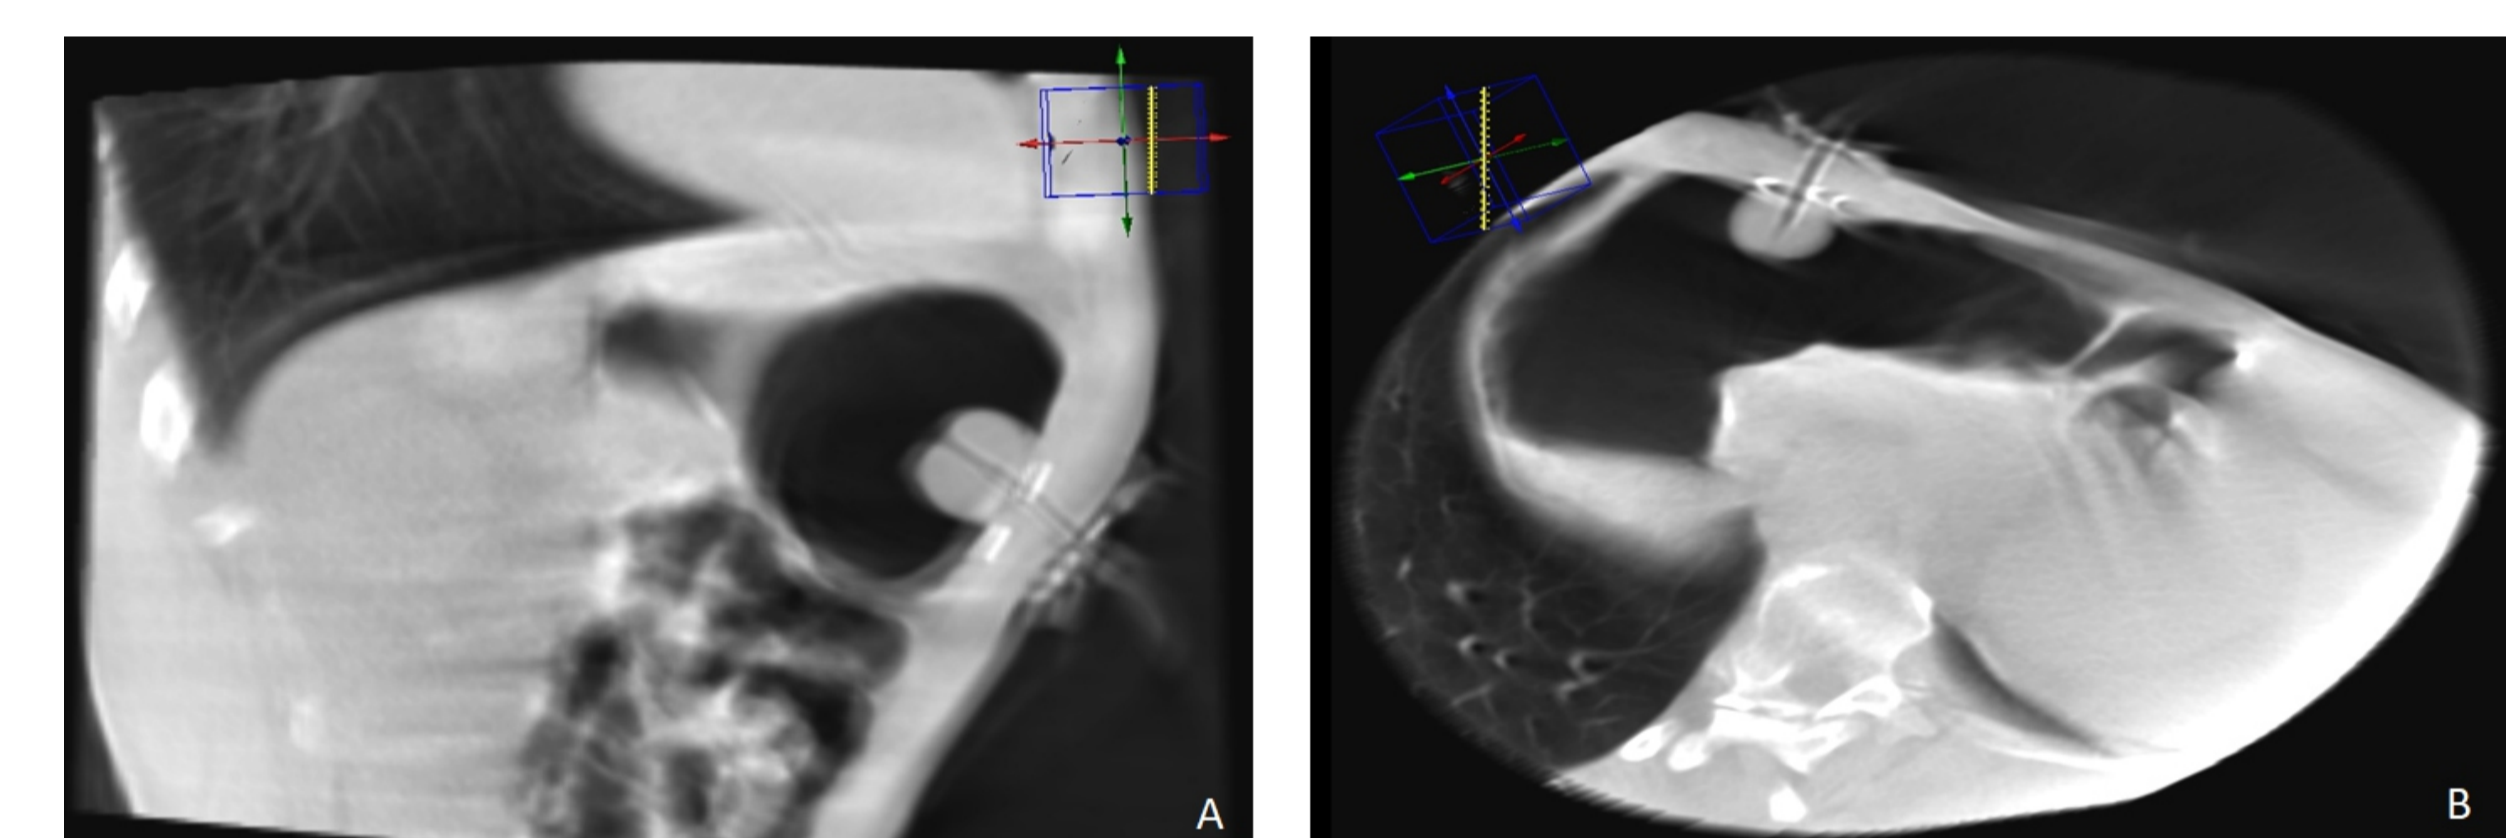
(A/B) Multiplanar reconstruction using cone beam technique to confirm the final tube position. Sagittal (A) and axial (B) images.
